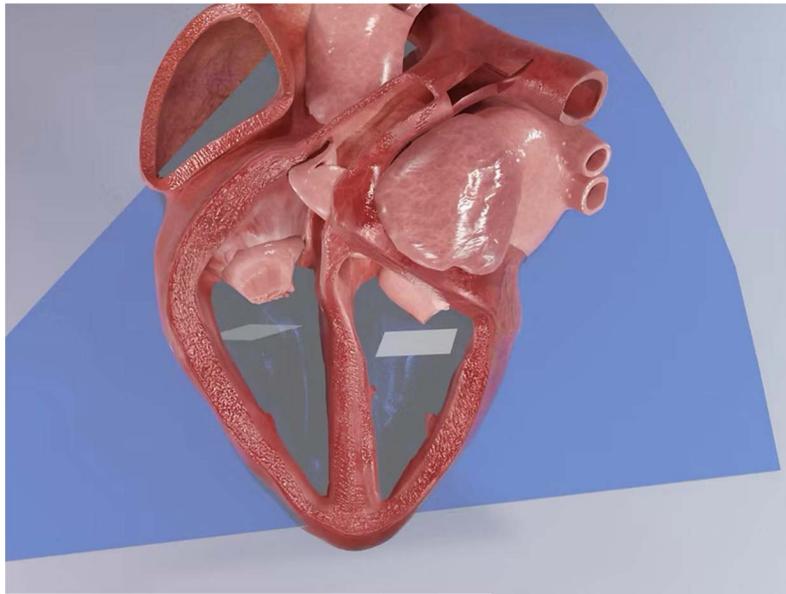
Three-dimensional (3D) animation of heart showing subcostal ultrasound (US) plane⁵.
